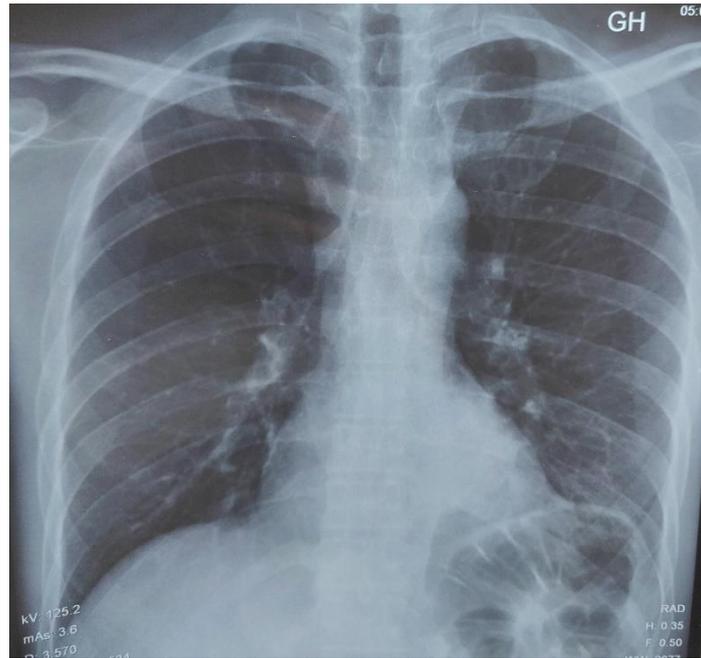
Front chest X-ray showing a left basal pulmonary opacity
